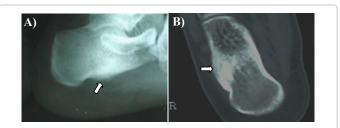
Case 1 (1a) X ray and (2b) CT of right calcaneal osteoid osteoma.
